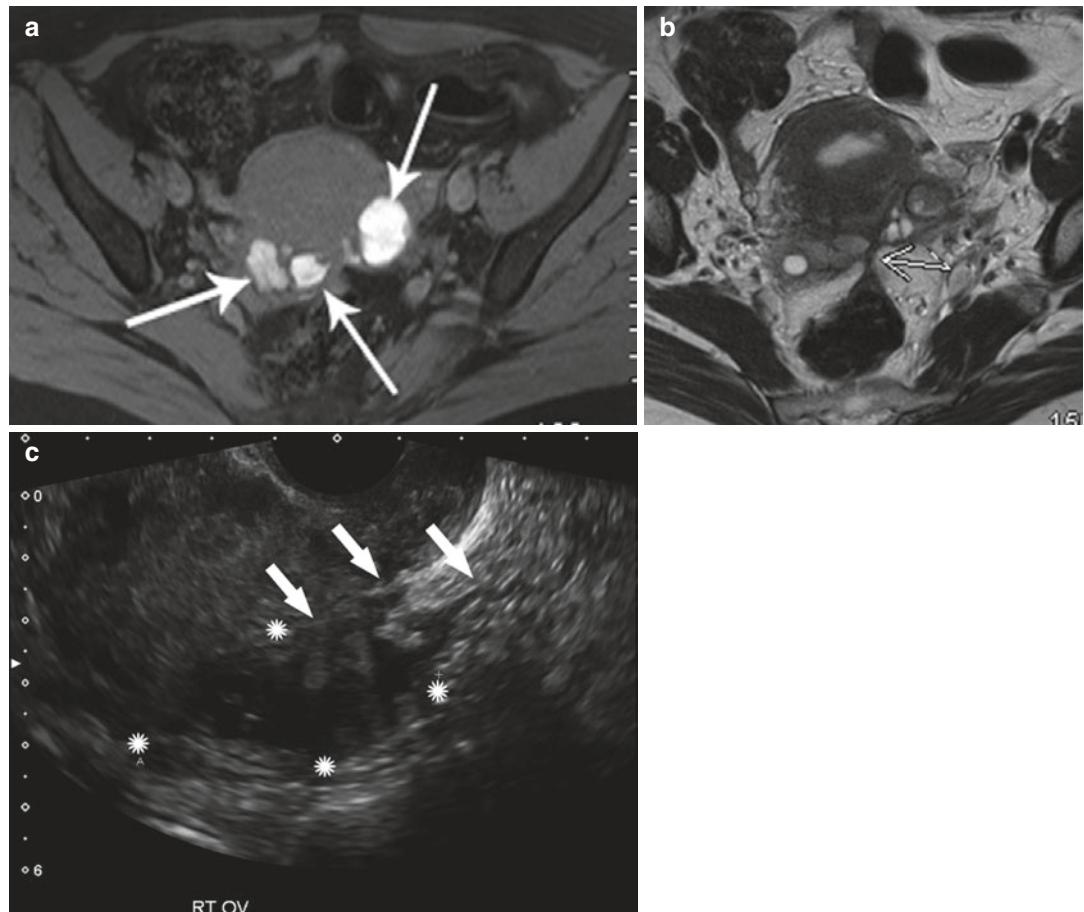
(a) Follow-up MR done on a 43-year-old woman with acute-on-chronic pelvic pain. The initial diagnosis was missed on ultrasound. Endometriosis deposits are seen as high signal intensity on the fat-saturated T1-weighted axial MR image (white arrows). (b) Axial T2 MR showing a low signal intensity linear
